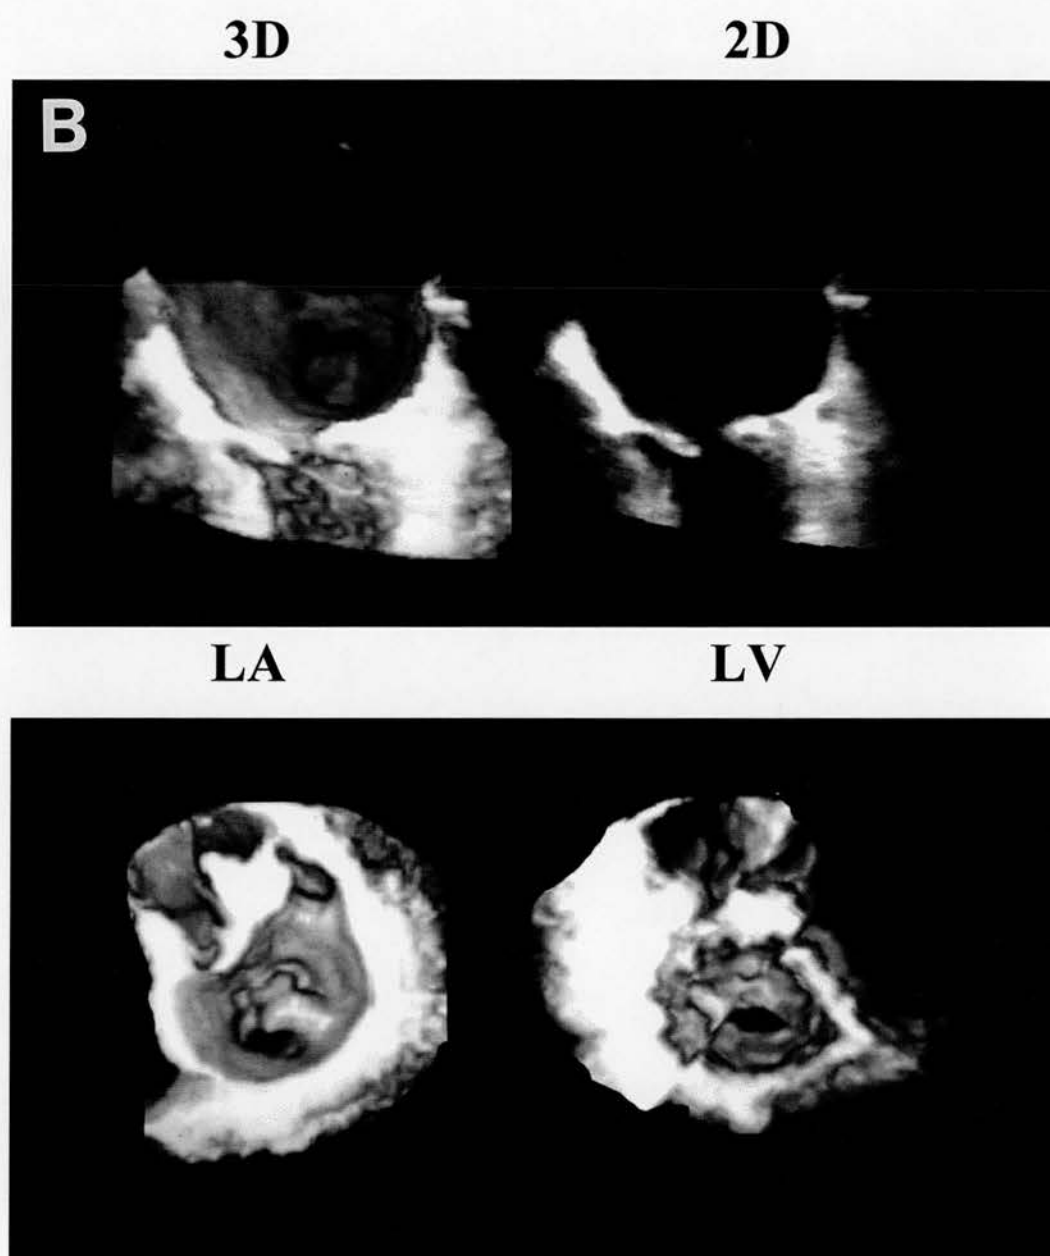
(cont'd). Examples of transoesophageal three-dimensional (3D) reconstruction of a stenotic mitral valve. (B), top - long-axis view with the corresponding two-dimensional (2D) image on the right hand side; bottom - reconstruction of the mitral valve *en face*, corresponding left atrial - (LA) and left-ventricular perspective (LV). Small slightly eccentric orifice. Extensively thickened and irregular surface of the anterior leaflet suggesting the presence of calcification. From the atrial perspective, the outline of commissural fusion is difficult to trace. Well visualised outline of the extent of commissural fusion from the ventricular perspective.
